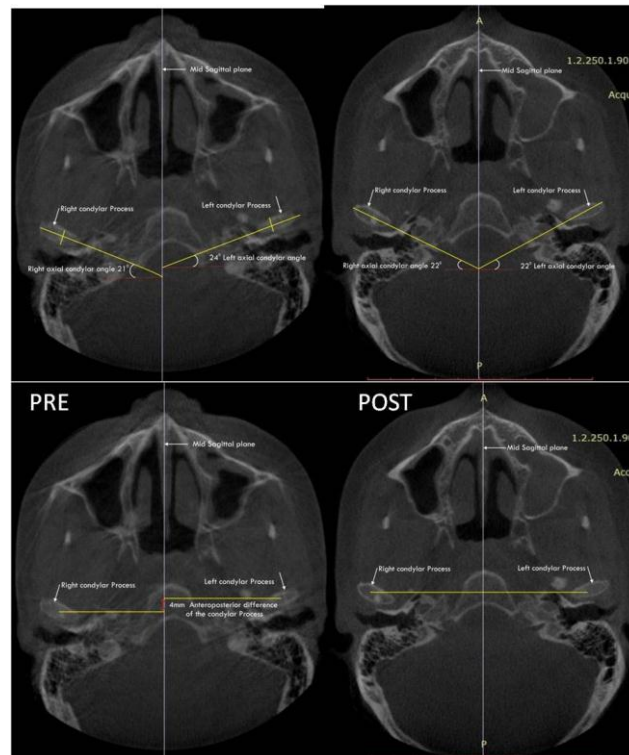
CBCT scans before and after occlusal deprogramming
